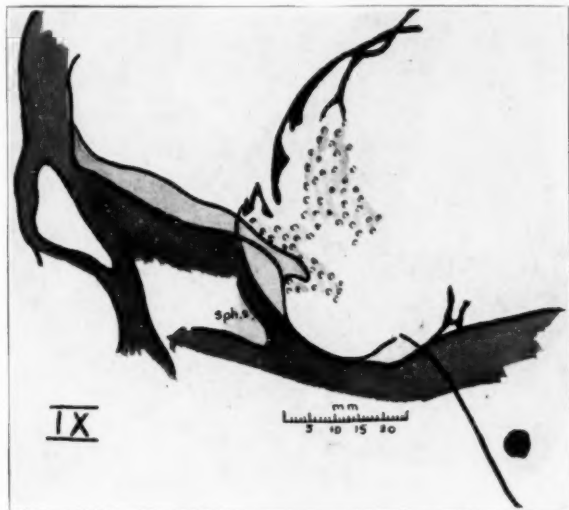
(case 9).—A sketch of the roentgenogram (fig. 29), drawn to scale.
